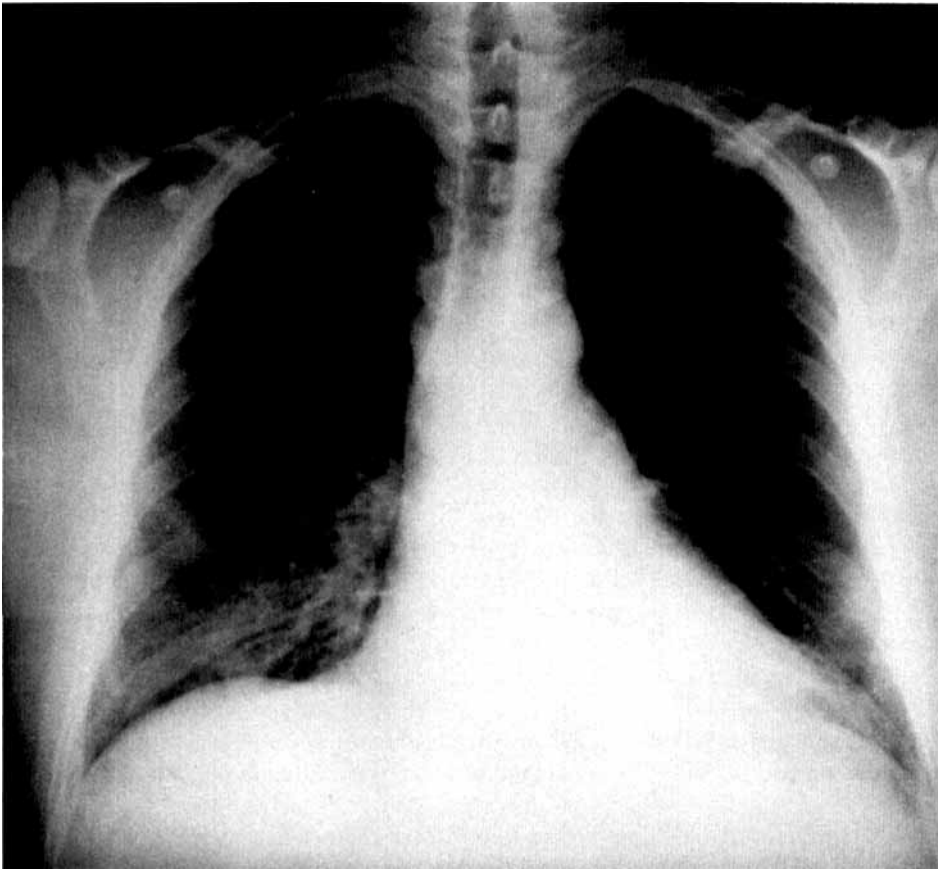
Chest radiographic infiltrates on admission to hospital of patient with illness related to compost handling.
